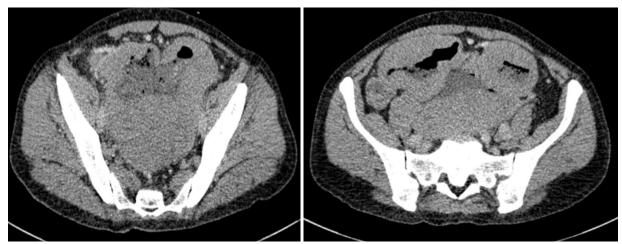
Axial CT scan: Small intestine GIST
